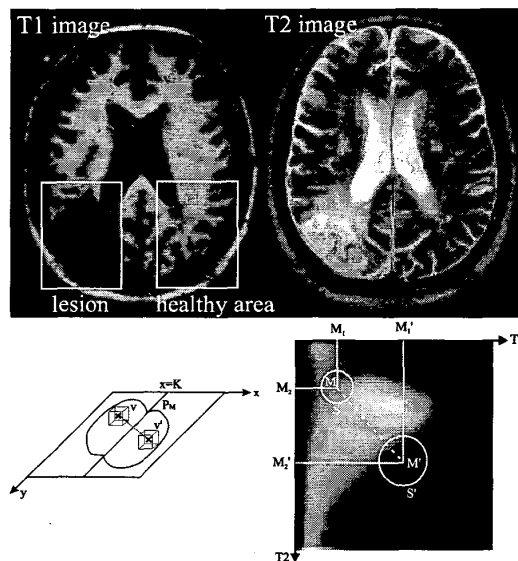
Top: A typical unilateral lesion as revealed by a  $T_1$  (left) and a  $T_2$  weighted (right) MR image. Lesions are detected as significant differences in the signal statistics between small homogeneous subregions (below).
